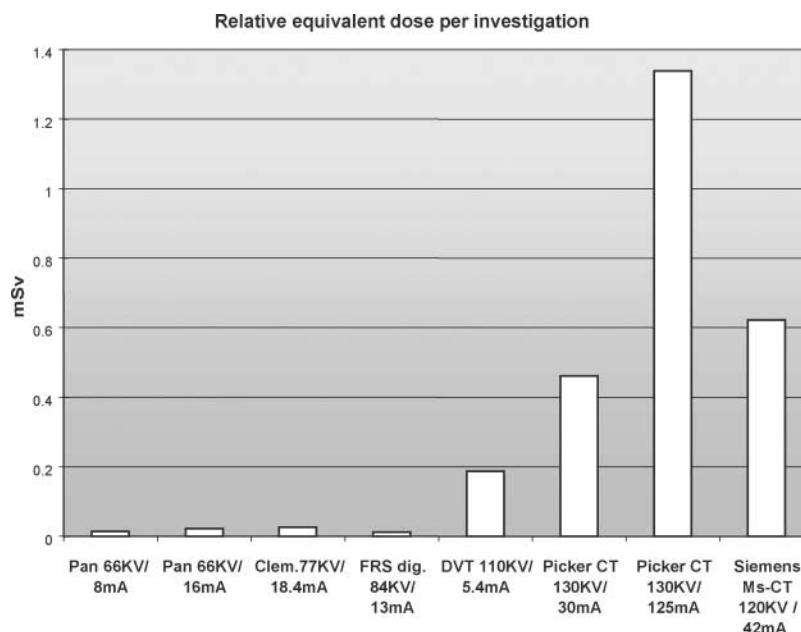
Graphic representation of the relative equivalent dose per investigation in mSv. OPG, orthopantomogram; OFS, occipito-frontal scan; LH, lateral head film; DVT, digital volume tomography; CT, computed tomography, either Picker or Siemens
